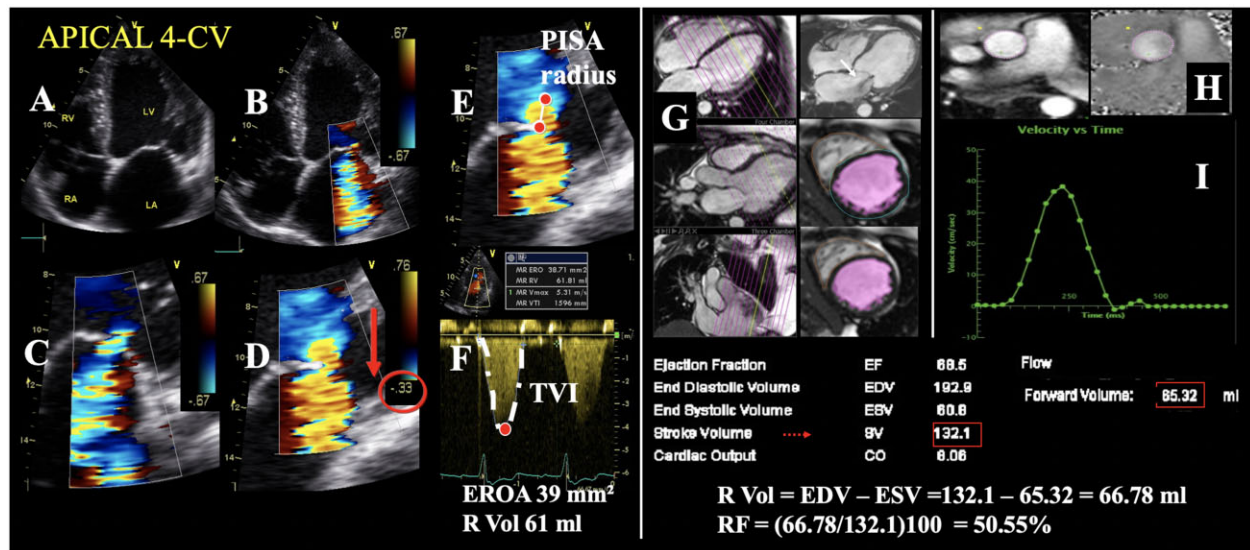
Quantitative assessment of MR severity using the PISA method (A–F) and the indirect CMR method (G–I). Stepwise analysis of MR. (A) Apical four-chamber view (CV). (B) Colour-flow display. (C) Zoom of the selected zone. (D) Downward shift of zero baseline to obtain a hemispheric PISA. (E) Measure of the PISA radius using the first aliasing. (F) Continuous wave Doppler of MR jet allowing calculation the effective regurgitant orifice area (EROA) and regurgitant volume (R Vol). TVI, time-velocity integral. CMR: White arrow: extent of the signal loss on cine CMR. (G) Assessment of LV volumes using cine images; (H) phase-contrast velocity mapping at the aortic root level; and (I) flow-time curves computing forward aortic flow.
